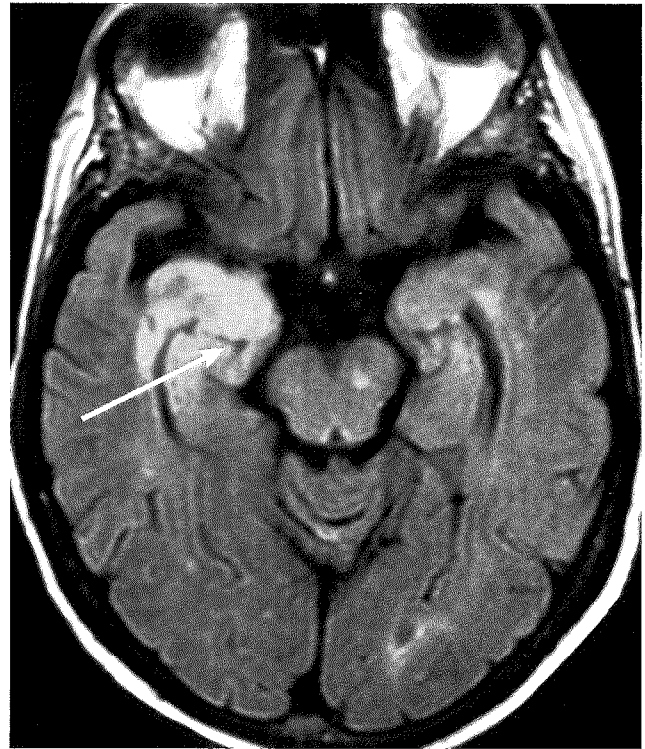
Brain MRI exhibiting right temporal lobe enhancement (arrow) in a patient with herpes simplex encephalitis.
